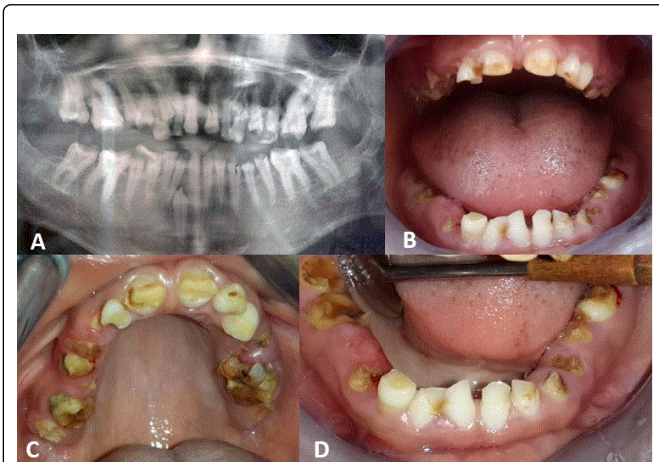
(a) OPT view of the patient showing radiographic features. (b) Frontal view of the maxillary and mandibular arch before the treatment. (c) Occlusal view of the upper arch before the treatment. (d) Occlusal view of the lower arch before the treatment.
